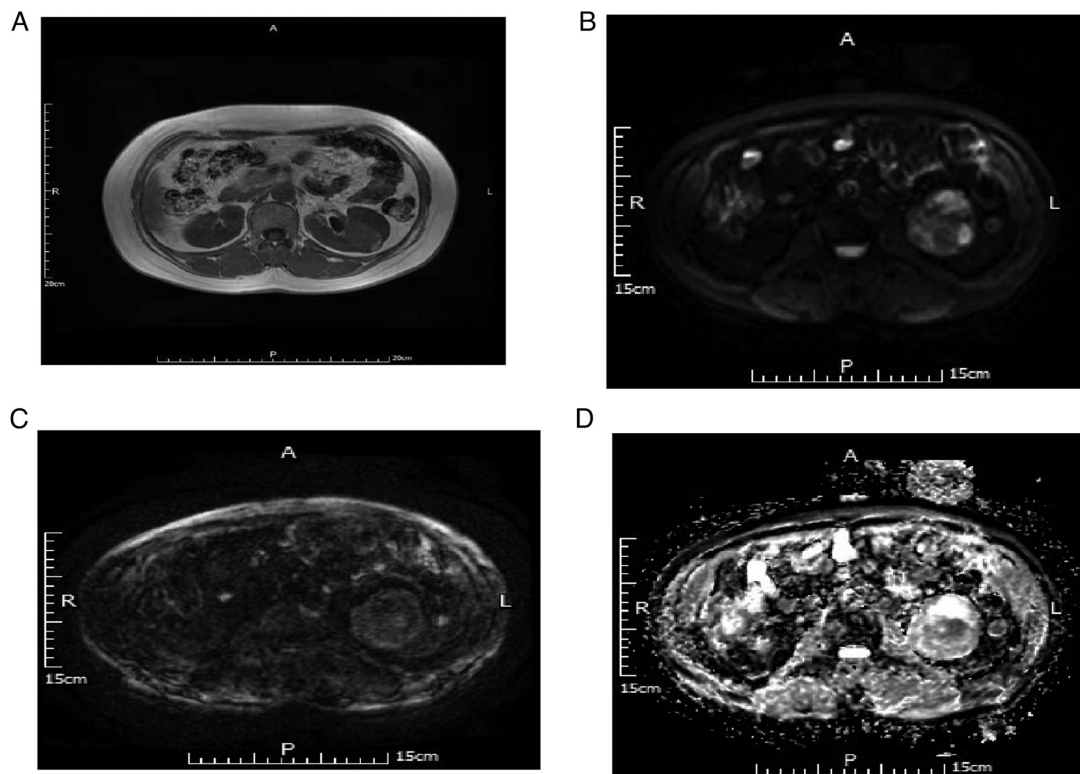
MRI scans of a 62-year-old male with pathologically confirmed renal clear cell carcinoma of the left kidney. (A) T1WI, left renal tumor with low signal. (B) DWI B=50, left renal tumor with high and low confounding signal. (C) DWI B=800, left renal tumor with low confounding signal. (D) Apparent diffusion coefficient with slightly high signal. DWI, diffusion-weighted imaging.
